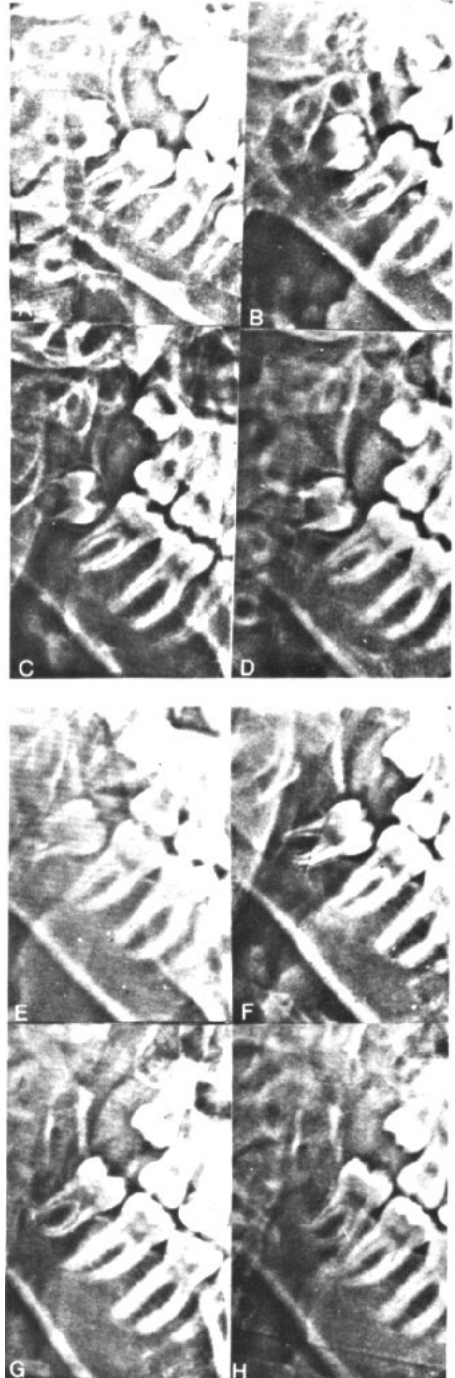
From annual 60° lateral cephalometric radiographs showing the development of a mandibular third molar which erupted.
